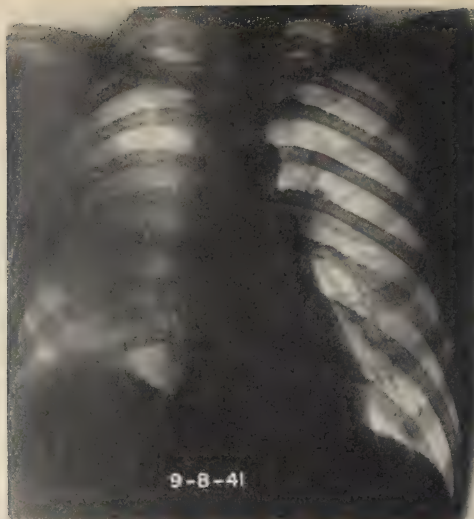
Roentgenogram showing shadow of huge pulmonary infarct in right pulmonary field
